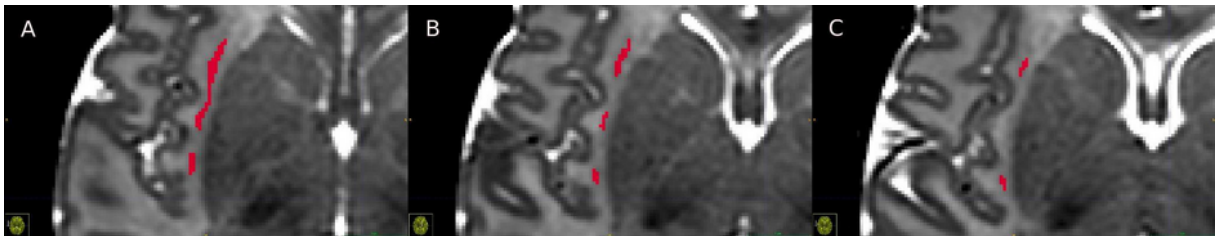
Dorsal axial MRI slices with manual claustrum segmentation.
